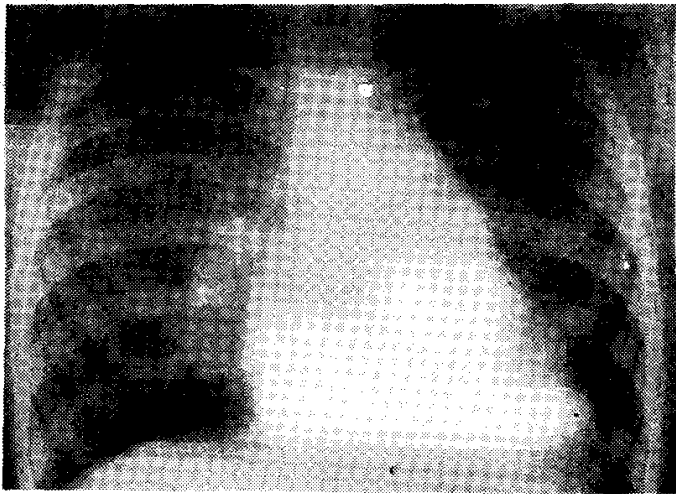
X-ray chest of a 5-years old child with PDA showing cardiomegaly, pulmonary plethora and the straight line sign; the pulmonary artery is also dilated.
